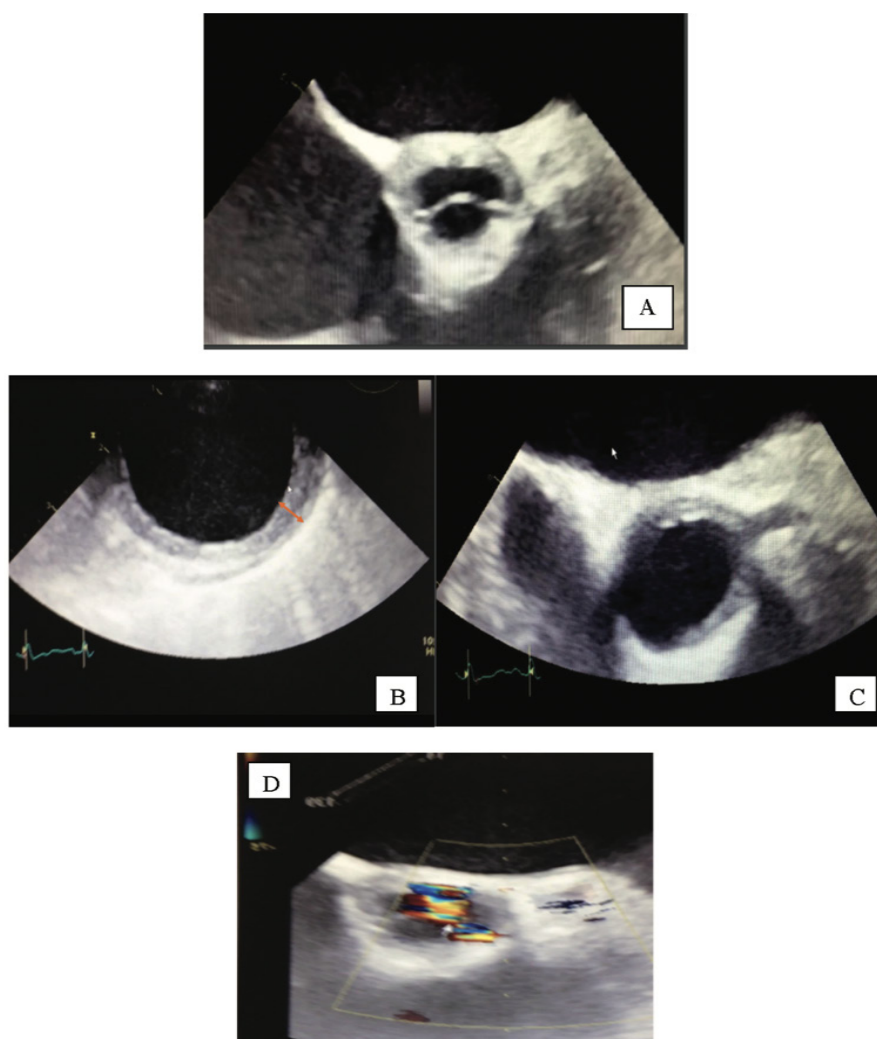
Echocardiography demonstrating limited mobility of the posterior and left anterior cusp leading to an aortic insufficiency (A). Circumferential and hypoechoic thickening of the aortic wall demonstrating BD-related aortitis (B) with an extension toward the left main trunk causing stenosis (C). Ensheatment of the two aortic cusps resulted in valvular restriction with aortic regurgitation (D). (Original data).
